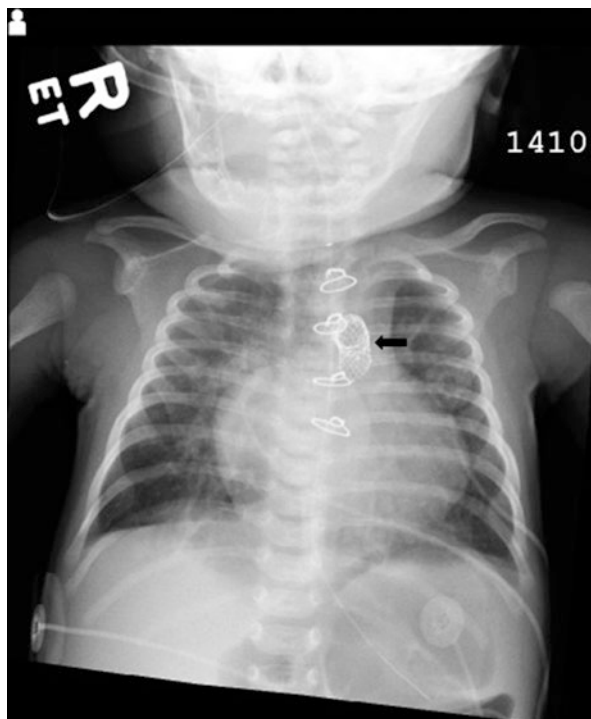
Chest radiograph showing the stent placed in the ductus arteriosus to keep systemic-pulmonary communication open
